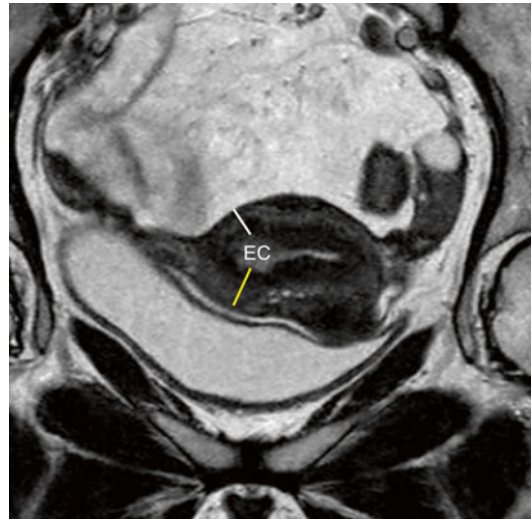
Quantification of the depth of myometrial infiltration. The percentage of myometrial infiltration can be calculated by dividing the disease-free myometrial thickness (*white line*) in the site of uterine wall involved by endometrial carcinoma (*EC*) for the physiological myometrial thickness in an analogue uninvolved position (*yellow line*) and by multiplying the obtained value by 100. On this axial TSE T2-weighted image (TR/TE 2,400/76 ms), the calculated percentage of myometrial infiltration is about 30 % (<50 %, stage Ia)
